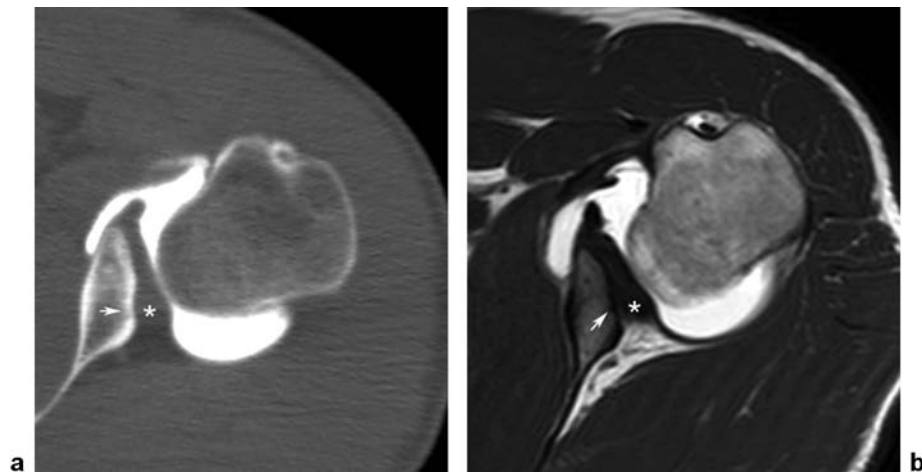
Glenoid dysplasia, severe posterior glenoid deficiency (arrow) is shown in the (a) CTA and (b) MRA with marked hypertrophied labrum (asterisk).
